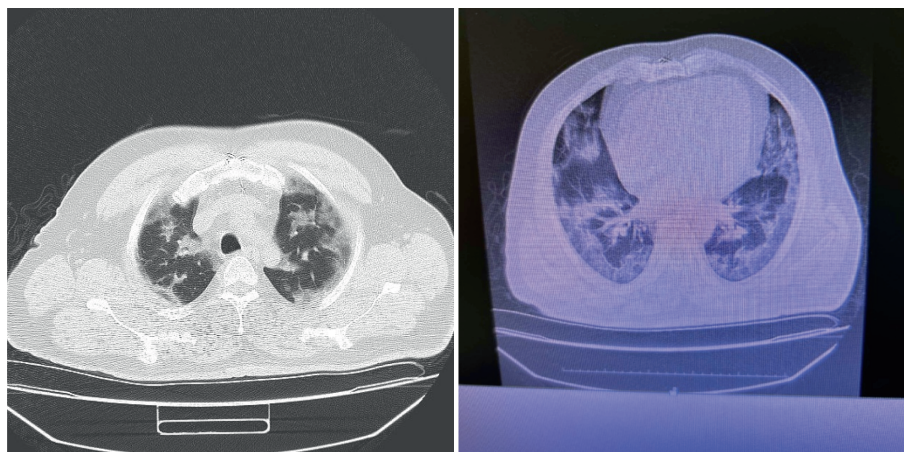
Diffuse ground-glass appearance starting from the apex in thorax CT.
